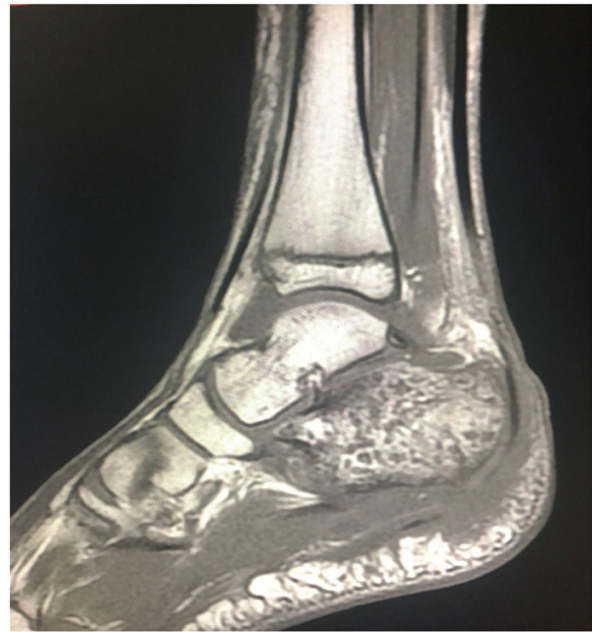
MRI Right Ankle Lateral View.
